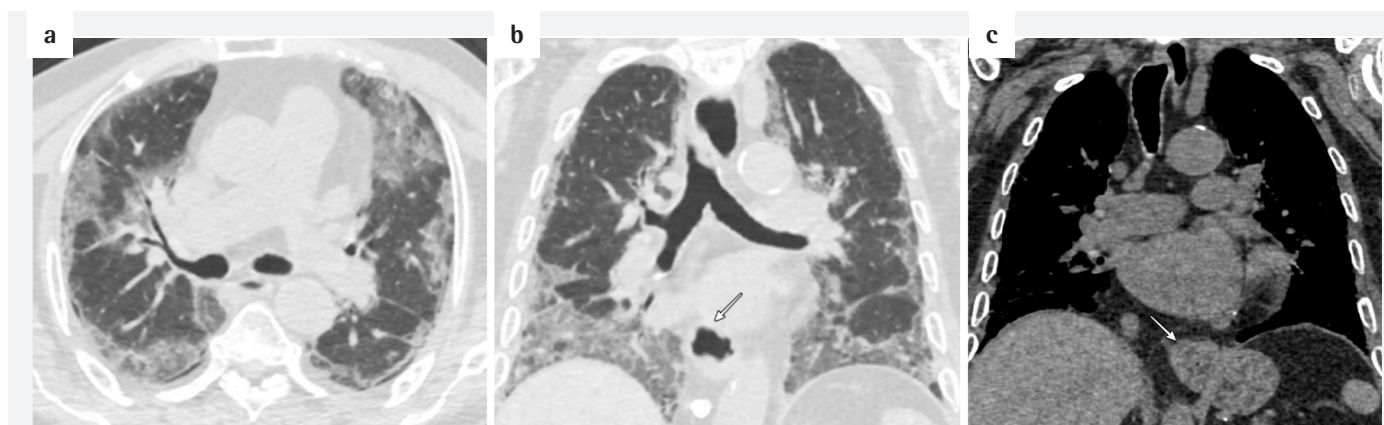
An 86-year-old man with confirmed Coronavirus disease-2019. His initial computed tomography (CT)-severity scores was calculated as 12. Axial (a) and coronal (b) lung window of unenhanced chest CT scans show bilateral ground-glass opacities with interlobular and intralobular septal thickening (crazy-paving pattern) with hiatal hernia. The coronal (c) mediastinal window of CT shows a part of the stomach sliding up into the chest through the hiatus. The patient died after being treated in the intensive care unit for 5 days
